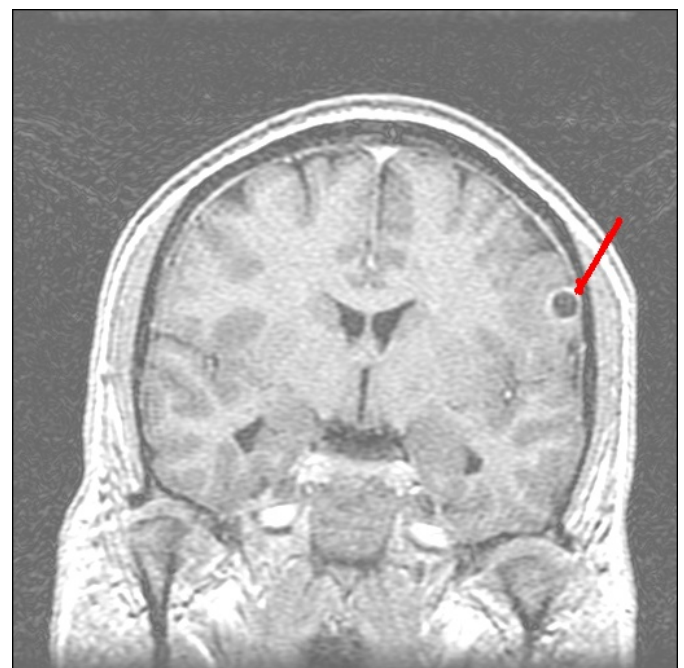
MRI of brain (T1 sequence) with contrast showing a solitary left cortical ring enhancing lesion, with no definite scolex visible within it indicated by the red line.
